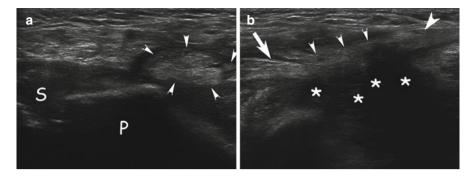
Casual acute complete avulsion of the whole aponeurosis with preserved continuity of both the adductor longus and rectus abdominis tendons. On the transverse sonographic scan (a) on the level of pubic symphysis (*S*), the cross-section of the avulsed and laterally (from the "bare" pubic tubercle (*P*)) displaced aponeurosis is visible (*arrowheads*) (b) shows a sonographic scan along the displaced complex of the adductor longus tendon (*arrowheads*), aponeurosis (*small arrowheads*), and ipsilateral rectus abdominis (*arrow*) surrounded by hematoma (*asterisks*)
